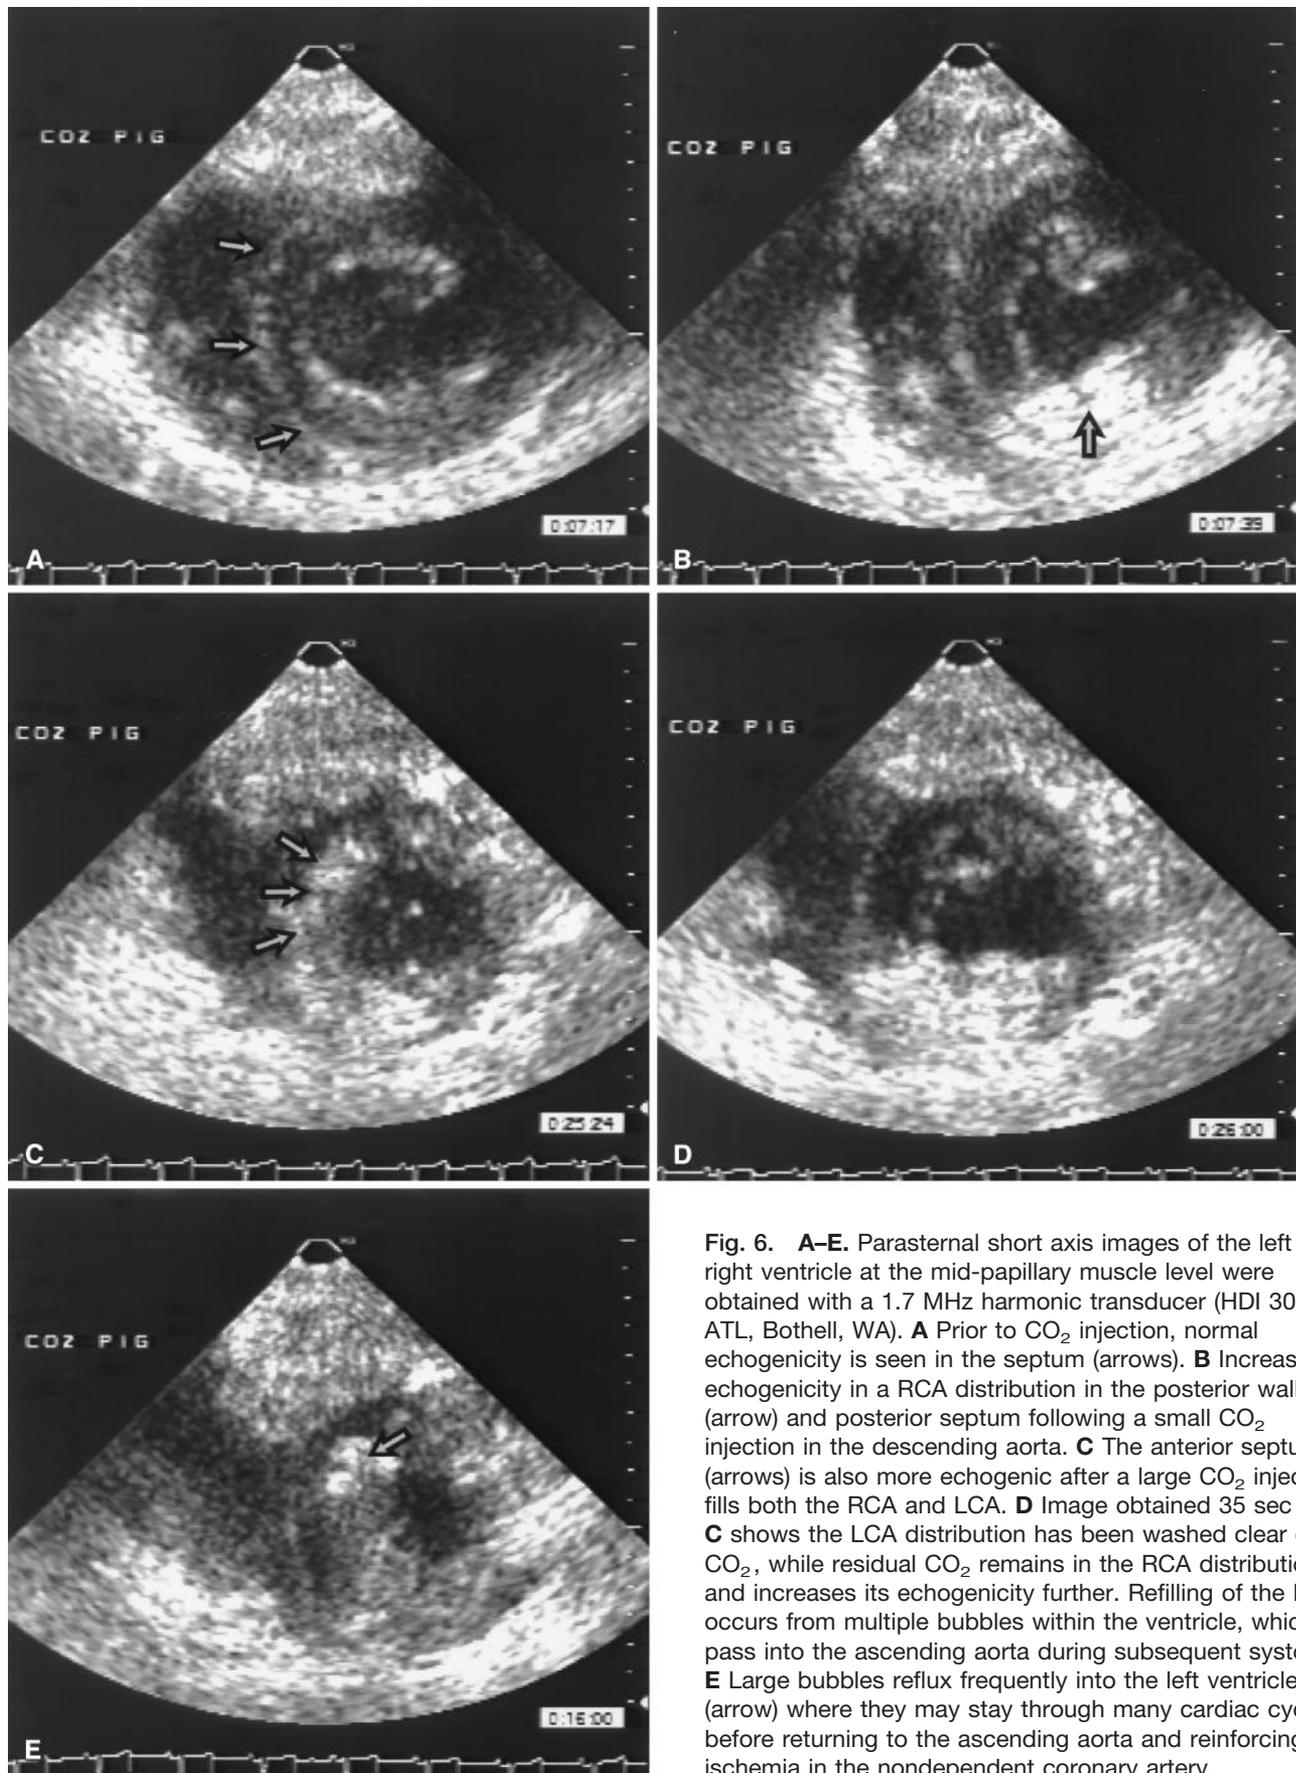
A–E. Parasternal short axis images of the left and right ventricle at the mid-papillary muscle level were obtained with a 1.7 MHz harmonic transducer (HDI 3000; ATL, Bothell, WA). A Prior to CO₂ injection, normal echogenicity is seen in the septum (arrows). B Increased echogenicity in a RCA distribution in the posterior wall (arrow) and posterior septum following a small CO₂ injection in the descending aorta. C The anterior septum (arrows) is also more echogenic after a large CO₂ injection fills both the RCA and LCA. D Image obtained 35 sec after C shows the LCA distribution has been washed clear of CO₂, while residual CO₂ remains in the RCA distribution and increases its echogenicity further. Refilling of the RCA occurs from multiple bubbles within the ventricle, which pass into the ascending aorta during subsequent systoles. E Large bubbles reflux frequently into the left ventricle (arrow) where they may stay through many cardiac cycles before returning to the ascending aorta and reinforcing the ischemia in the nondependent coronary artery.
